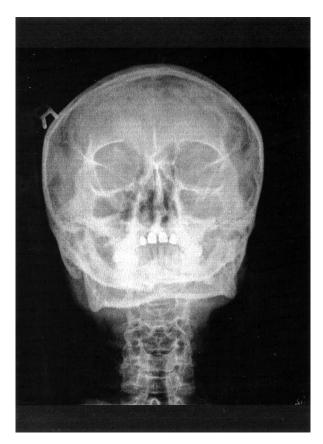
The Water's view radiograph shows opacity of the left maxillary sinus.
